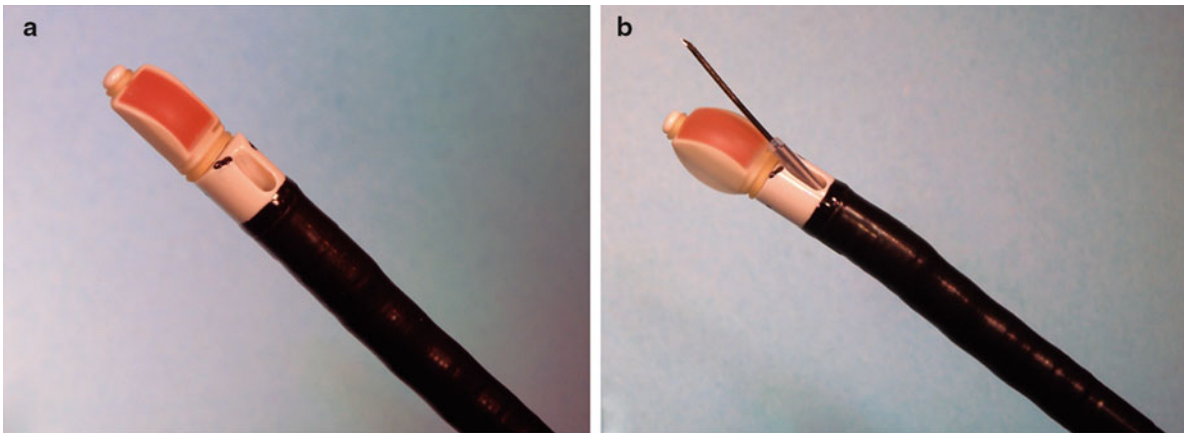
Tip of the new convex probe endobronchial ultrasound (CP-EBUS, BF-UC160F-OL8, Olympus, Tokyo, Japan). The outer diameter of the insertion tube of the flexible bronchoscope is 6.2 mm. CP-EBUS
